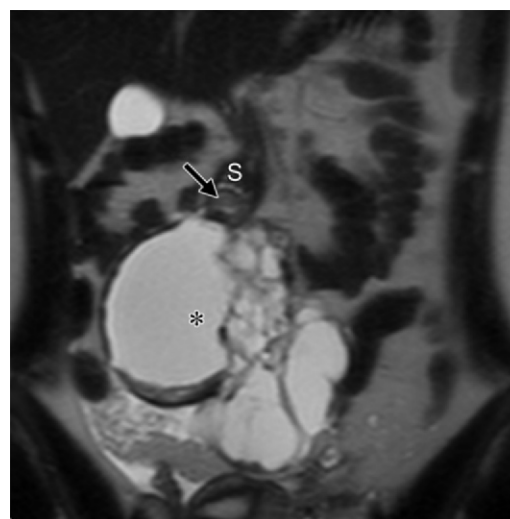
Coronal T2-weighted MR image shows the multiloculated cystic mass (*) arising (arrow) from the gastric antrum (S).
